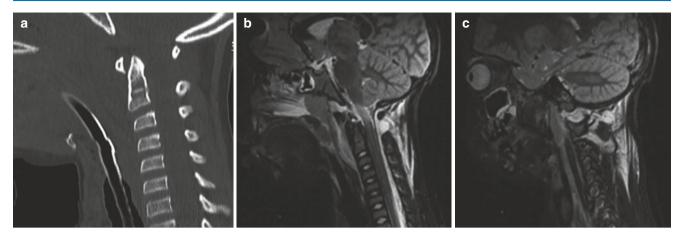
(a) CT of the cervical spine shows atlanto-occipital dislocation with anterior displacement of the occiput in relation to the atlas. MRI shows (b) diffuse soft-tissue oedema and focal oedema of the cervical spine and (c) increased distance between the occiput and the body of C1
